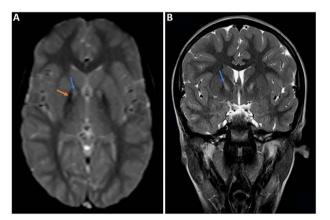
Brain MRI images in axial T2* sequence (A), coronal T2 sequence (B), showing at the level of both globi pallidi a hypersignal (vertical arrow) surrounded by a hyposignal (horizontal arrow), creating the 'eye of the tiger' appearance, more easily visible on the T2* sequence (A).
